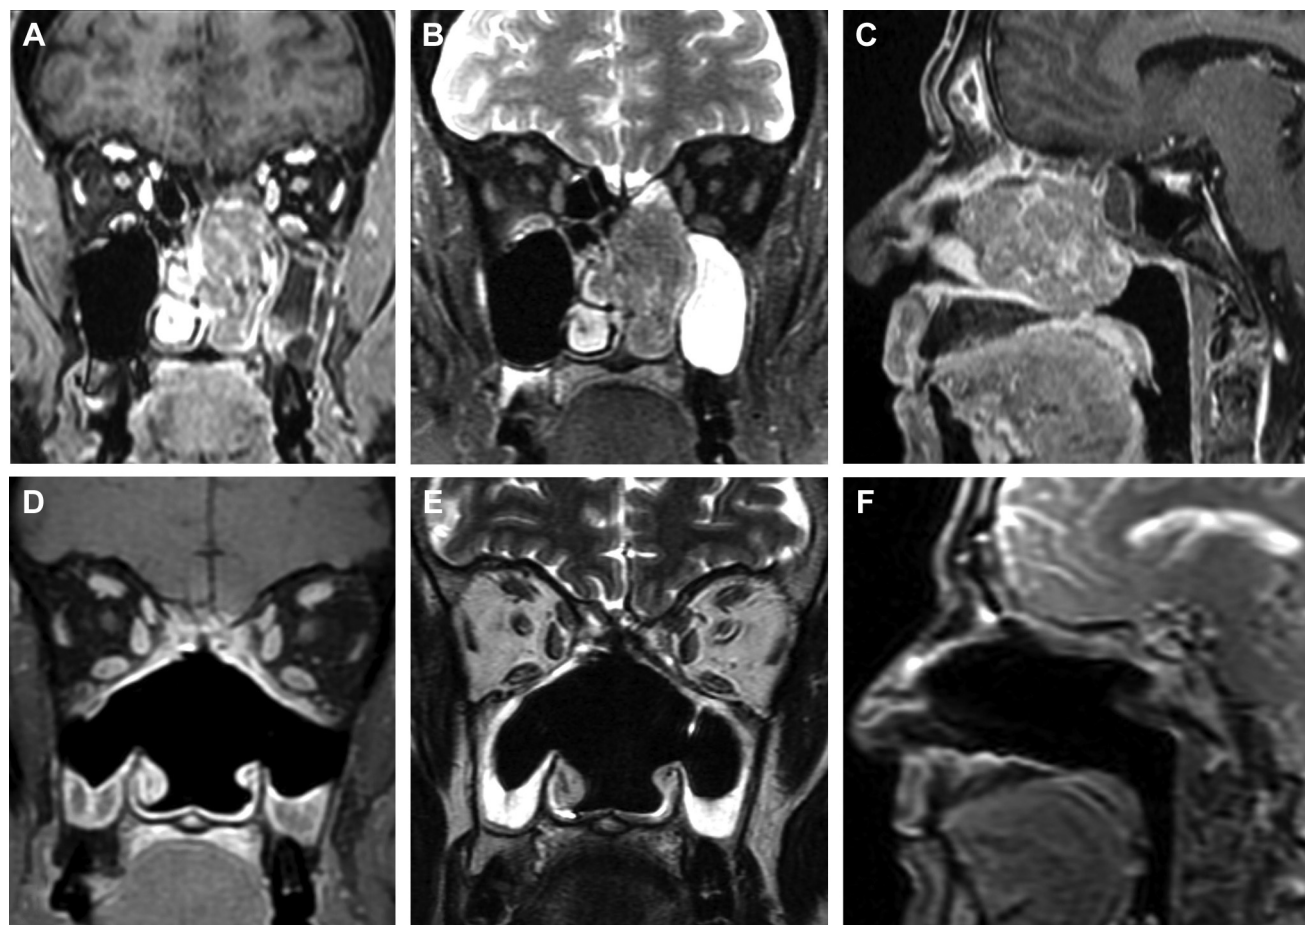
Endoscopic resection with transnasal craniectomy of ethmoidal intestinal type adenocarcinoma (stage T3N0M0) in a patient with occupational exposure to wood dusts. Preoperative contrast-enhanced T1-weighted (A) and T2-weighted (B) magnetic resonance imaging (MRI) scan in coronal view and contrast-enhanced T1-weighted MRI scan in sagittal view (C) showed a monolateral lesion without evident skull base involvement. However, the bilateral carcinogenic exposure of the patient
